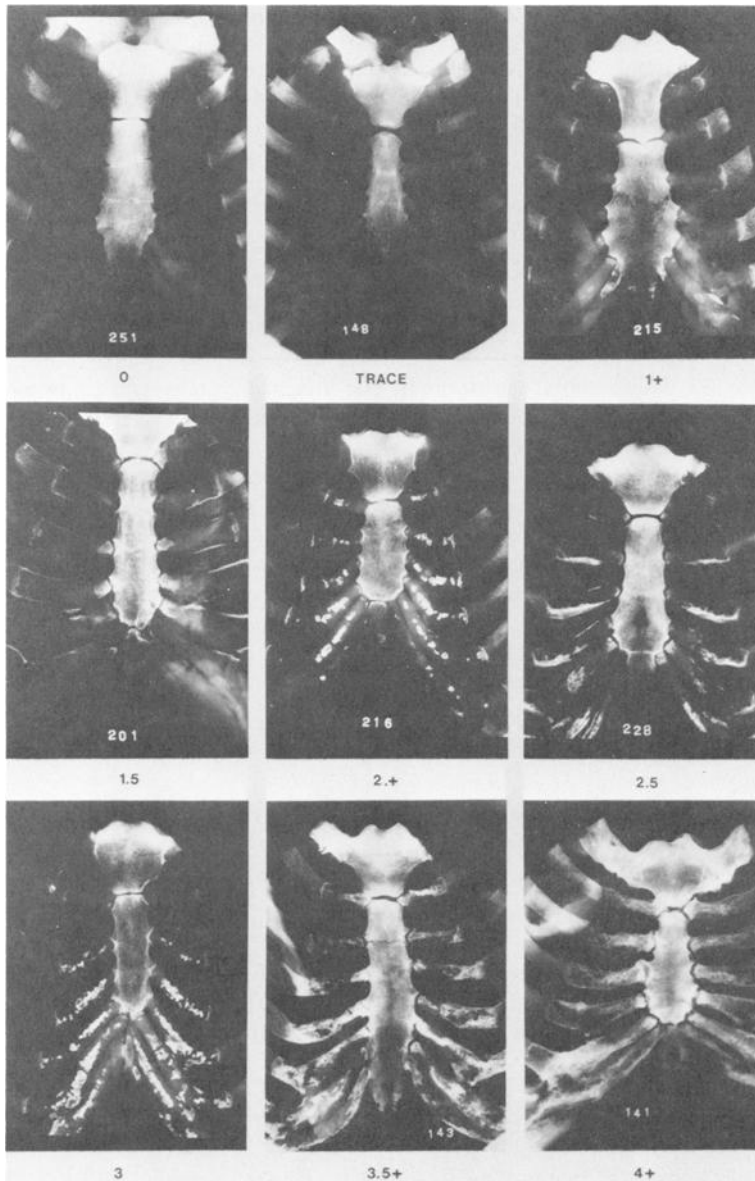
X-rays of chest plates with grading of mineralization of costal cartilages from 0 (none visible) to 4+ (very severe). This nine-point grading system was used to develop Fig. 2.
